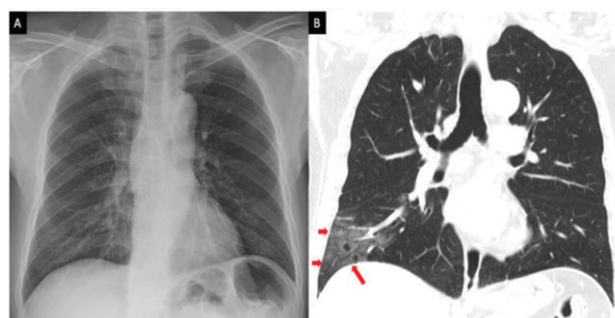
Normal CXR but obvious peripheral changes in CT (Study done 1 hour apart)
